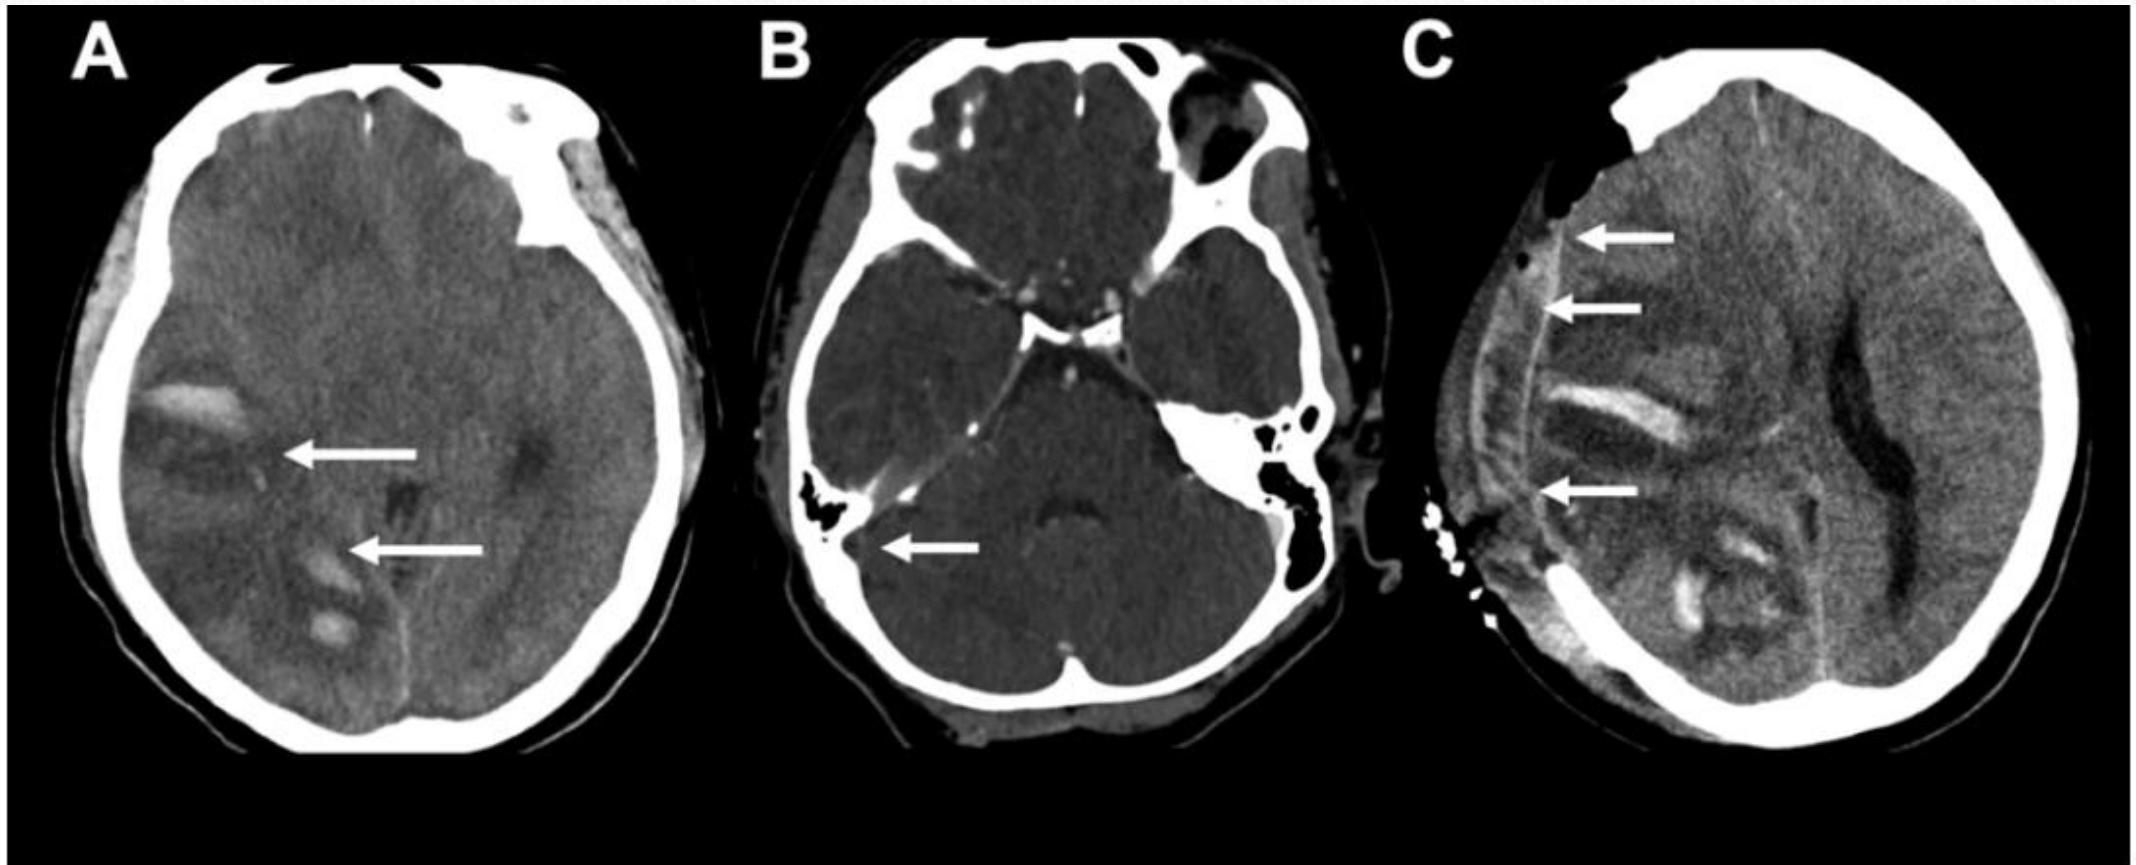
Transverse venous sinus thrombosis. (A) Area of haemorrhagic infarction of the right temporoparietal region not respecting arterial boundaries with swelling and oedema (white arrows); (B) CT venogram showing absent contrast filling of the right transverse sinus (white arrow); (C) severe haemorrhagic infarction with worsening mass effect that was treated with hemicraniectomy (white arrows).
